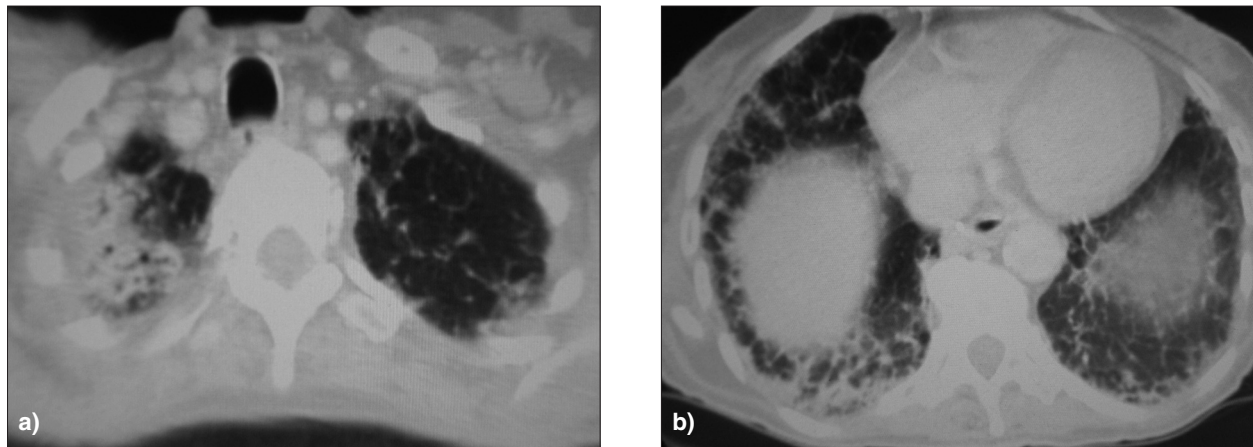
HRCT of the thorax demonstrating intralobular septal thickening at the periphery, bilateral lower lobe honeycombing with associated traction bronchiectasis (a) as well as a consolidation in the apical segment of the right upper lobe (b).
